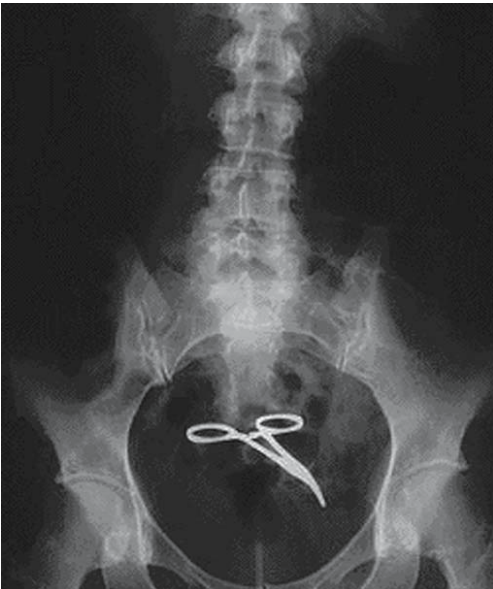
Abdominal X-ray. Retained surgical clamp
